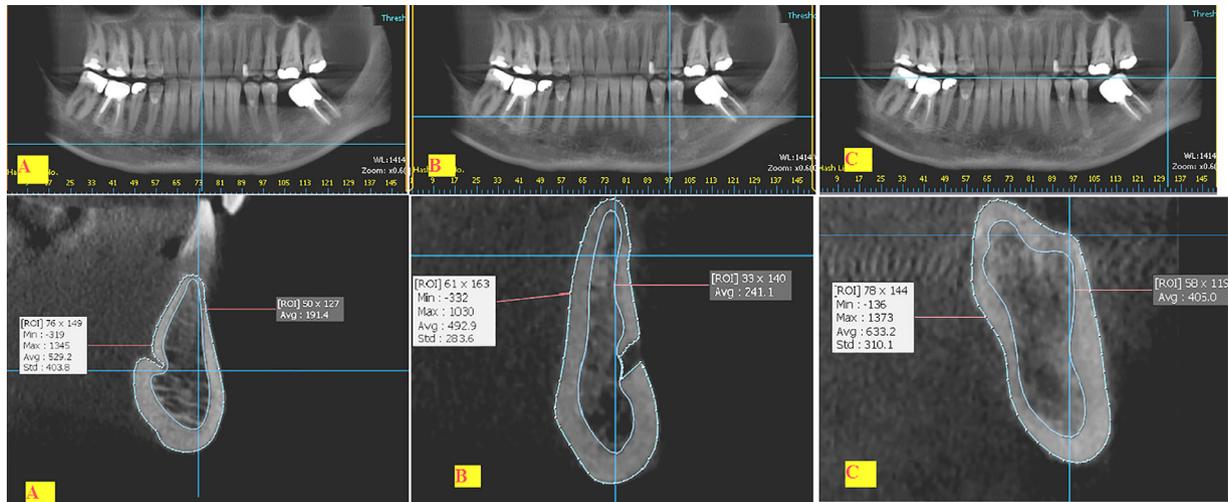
Cone beam computed tomography (CBCT) image, A, Gray values of cancellous and cancellous plus cortical bones at the site of the mandibular incisors, B, Gray values of cancellous and cancellous plus cortical bones at the site of the mandibular pre-molar, C, Gray values of cancellous and cancellous plus cortical bones at the mandibular retromolar area.
